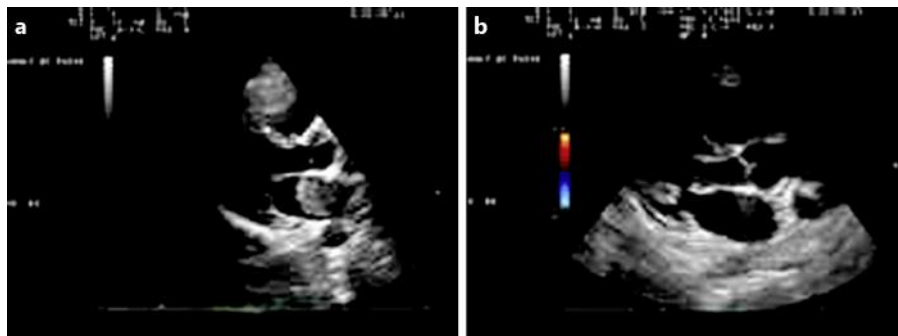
a Echocardiography showing LA tumor. b Echocardiography showing tumor-free LA after tumor resection.
